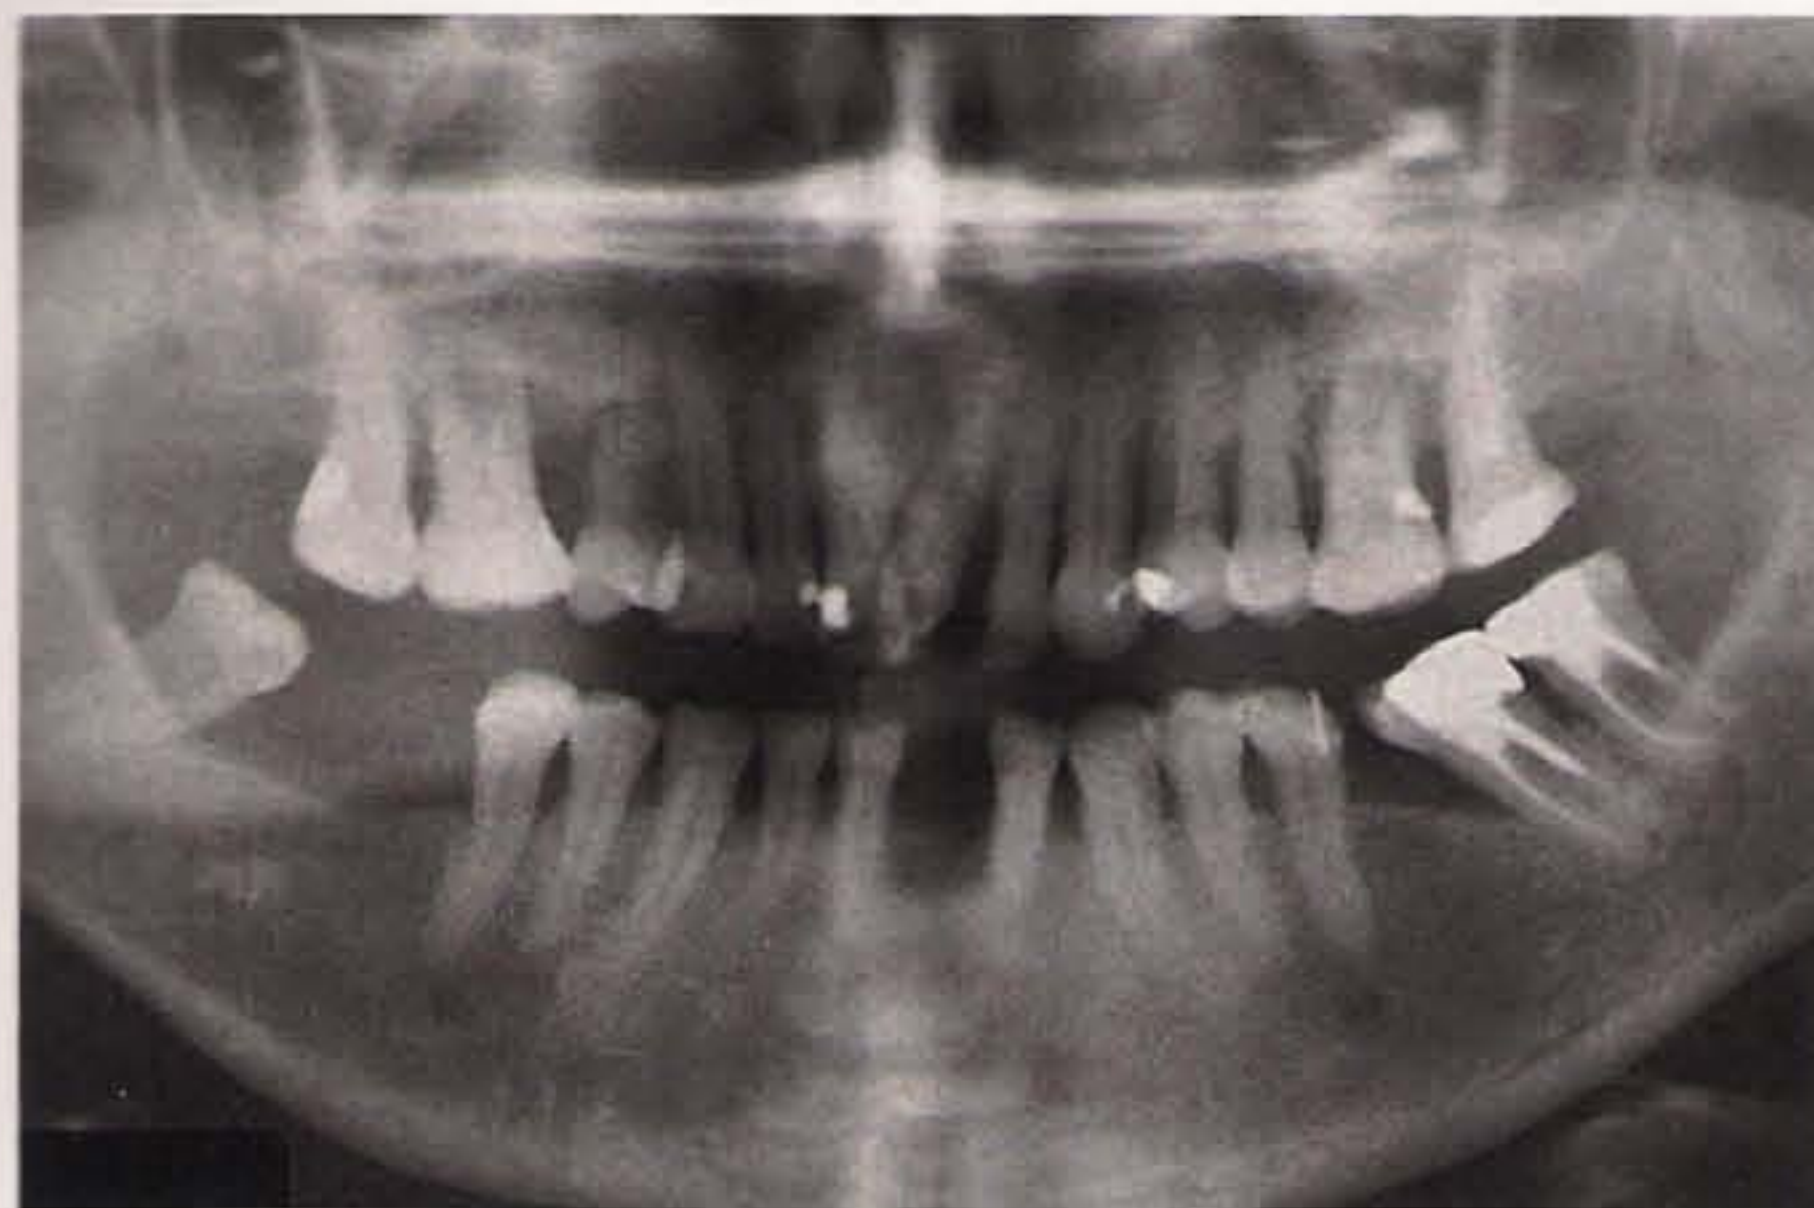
The panoramic radiograph reveals serious bone loss in both arches.
